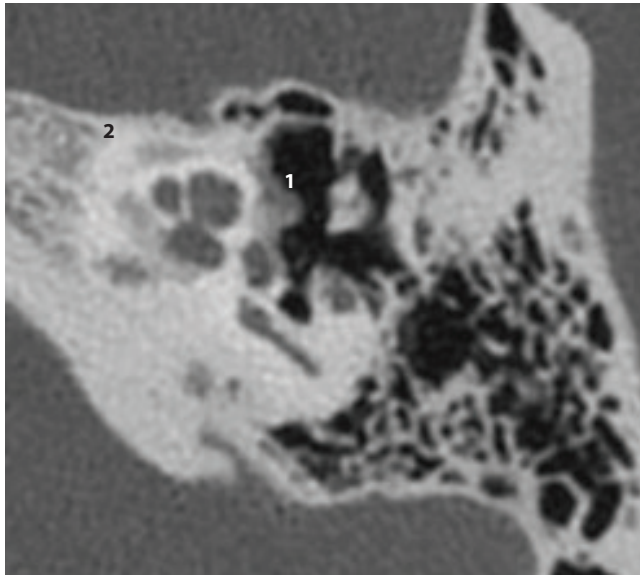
Axial CT scan of the left middle ear through the stapes footplate showing lucency anterior to the stapes footplate (1) and around the cochlear (2).
